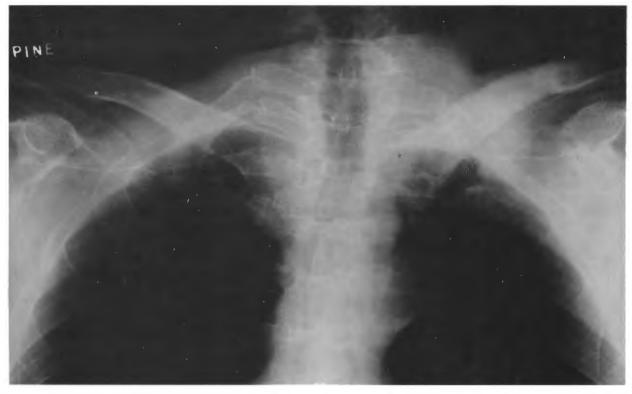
Radiograph of clavicle reveals coarsened trabecular pattern and sclerosis typical of Paget's disease.
